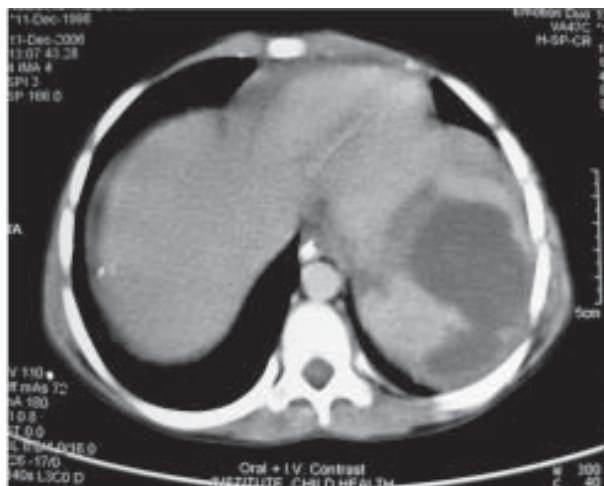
CT scan of abdomen showing splenic infarct.
